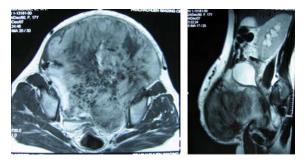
MRI revealed large lobulated mass in the pelvis
